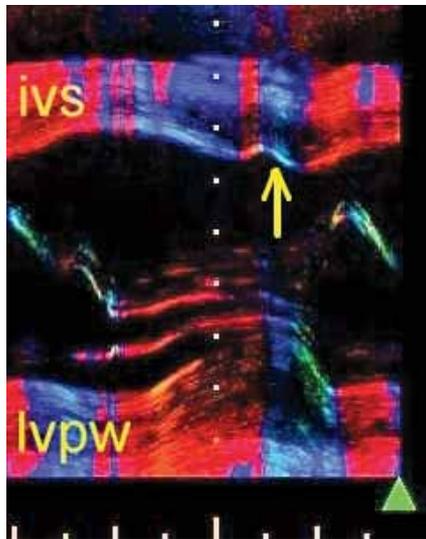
Double movement of the septum shown using colour tissue Doppler imaging in M-mode view. Legend: *ivs* – interventricular septum, *lvpw* – left ventricular posterior wall, arrow – secondary systolic movement.
